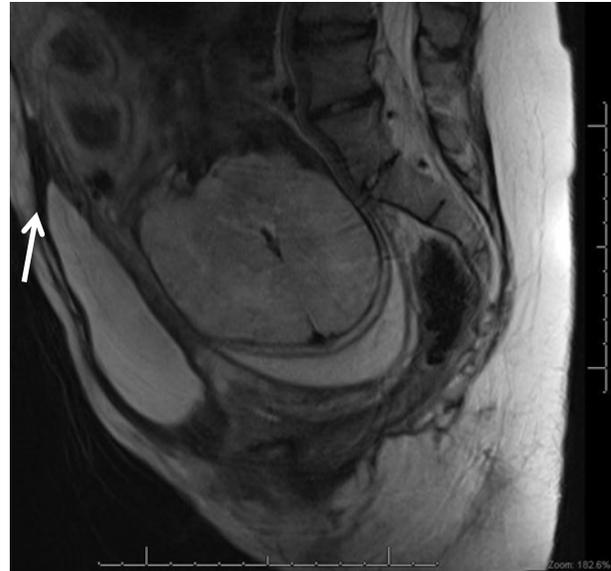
Sagittal view MRI of pelvis without contrast at 38 6/7 weeks from Case 1 demonstrating the bladder near the anterior abdominal wall and tethered high toward the umbilicus (arrow).
